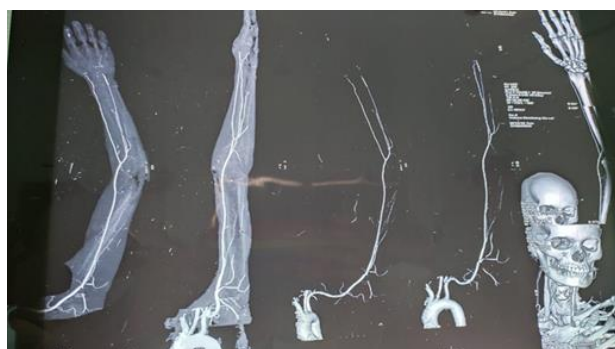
CT angiogram of left upper limb (14.09.21)
